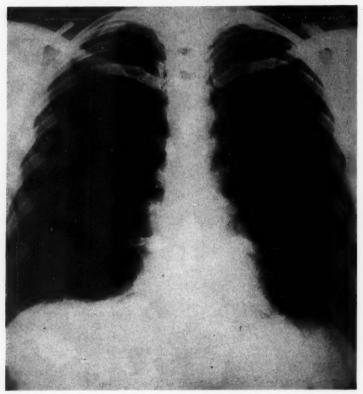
Roentgenogram of the chest of a patient with an asymptomatic, accidentally discovered coccidioidal granuloma of the apex of the left lower lobe. Mycelia, but no spherules, of *C. immitis* were found in the surgically resected lesion.
